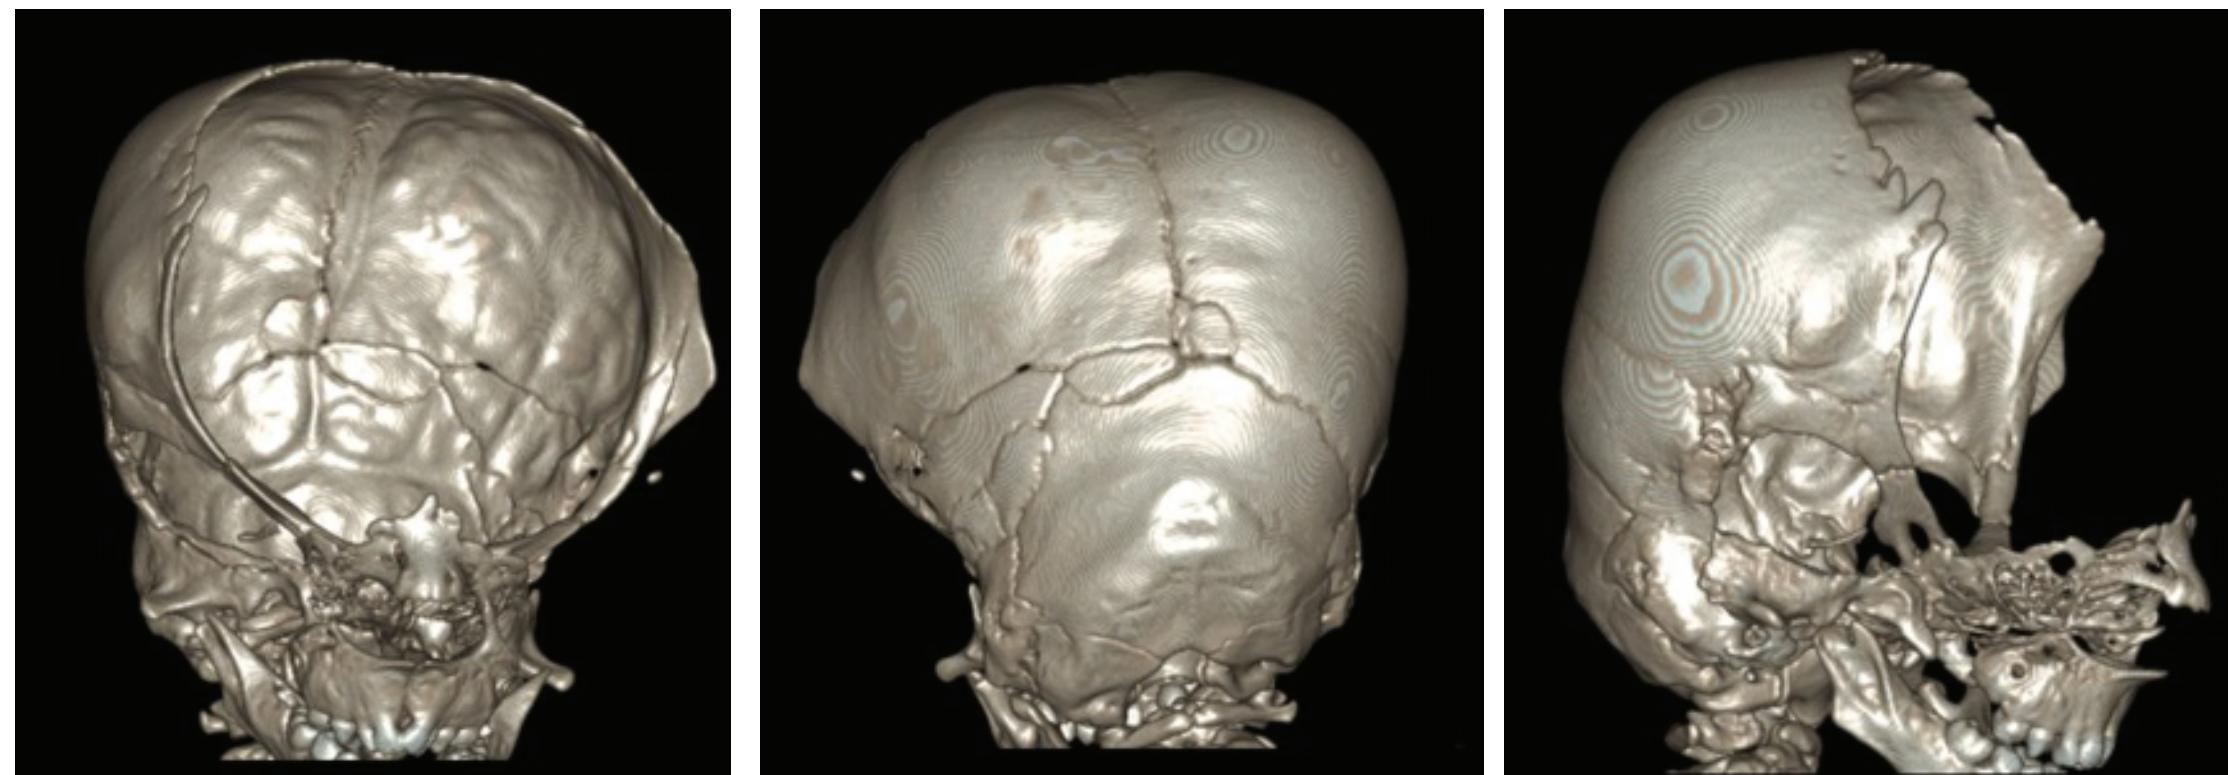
CT scan of patient with in Figure 9 at 18 months of age.
